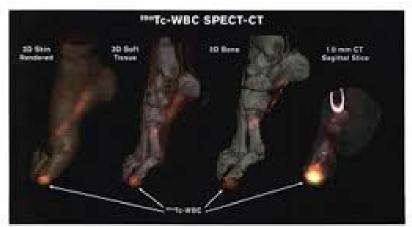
¹⁹⁹⁶Tc-WBC SPECT/CT hybrid image of diabetic foot with esteomyelius of first digit terminal taft. Extent, depth, severity, and hene involvement of infection were not clinically apparent. Hybrid image CSI score was 6. (A high-quality digital representation of this figure is available in the online tusie.)
